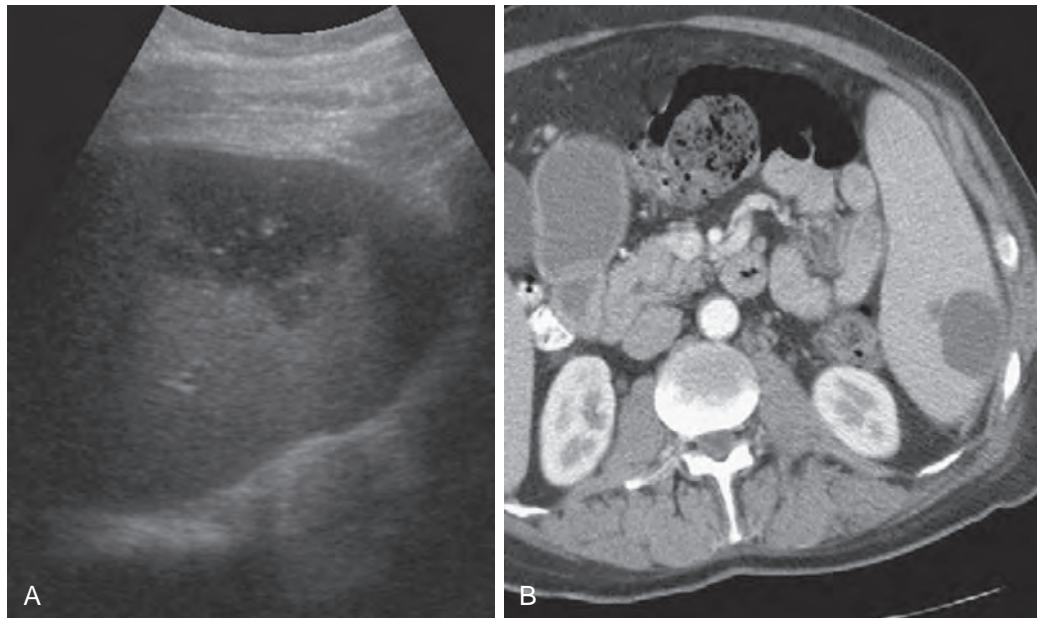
Malignant B-cell lymphoma in a 46-year-old man with subacute abdominal pain in the left upper abdomen. A. Focused sonography of the spleen demonstrates an anechoic peripheral area with some internal echoes. B. The enhanced helical CT scan during the portal venous phase shows a hypodense peripheral lesion and splenomegaly. Similar lesions were demonstrated in the liver (not shown).
